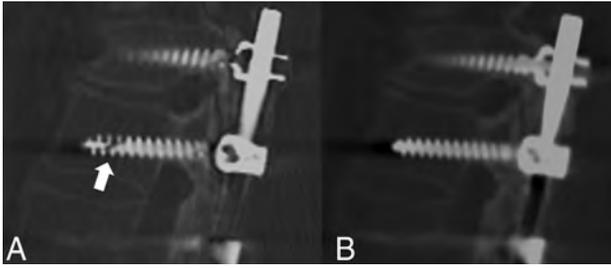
A, Sagittal CT image of posterior spinal fusion of the MAR protocol demonstrating lucency through the pedicle screw (*white arrow*). This lucency clearly mimics a fracture, hence could be called a “pseudofracture” if non-MAR images are not available. B, Image without the MAR application shows a normal appearance of the pedicle screw.
